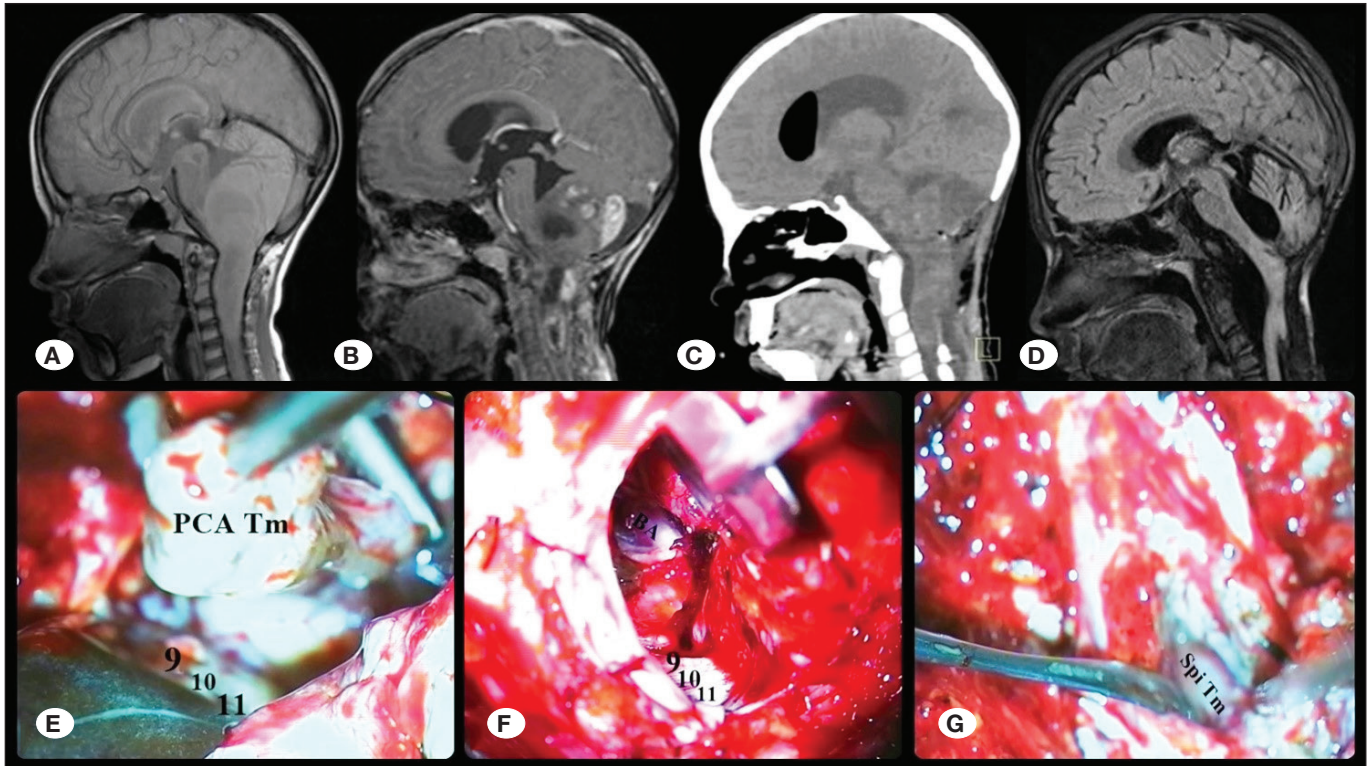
Patient #18. Pilocytic astrocytoma extending to the fourth ventricle, posterior cranial area (PCA), and cervicomedullary region. A) Preoperative T1W sagittal MR imaging. B) Multiple cystic structures and heterogeneous contrast enhancement in T1W sagittal MR image. C) Early postoperative CT scan. D) Late postoperative period (1 year after surgery). E–G) Cervicomedullary tumor with exophytic lateral extension into the PCA; postoperative follow-up shows resolution of hydrocephalus and gait disturbance.
